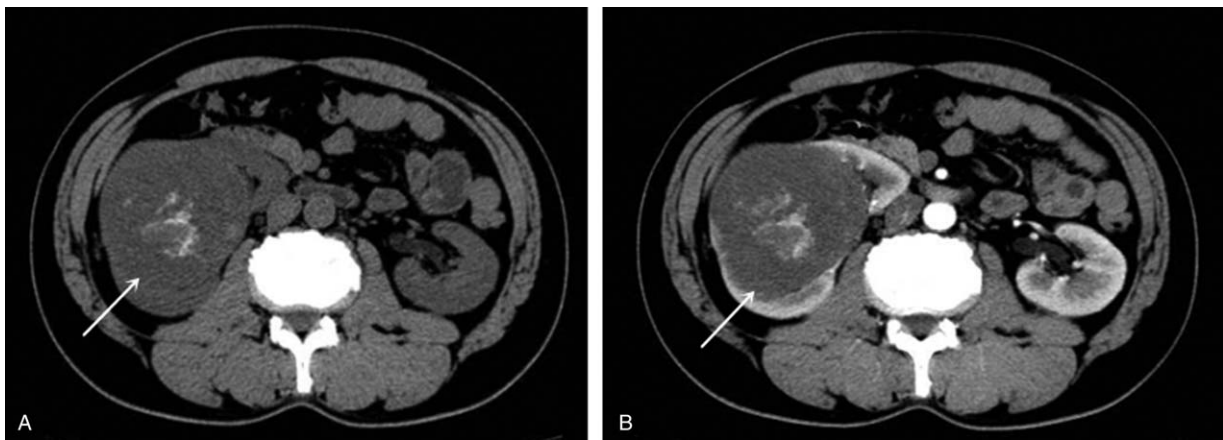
(A) Axial unenhanced CT-scan revealed a huge homogenous mass with patchy calcification in the central area (arrow). (B) Axial enhanced CT-scan showed the lesion (arrow) was slightly enhanced at the arterial phase after contrast injection.
